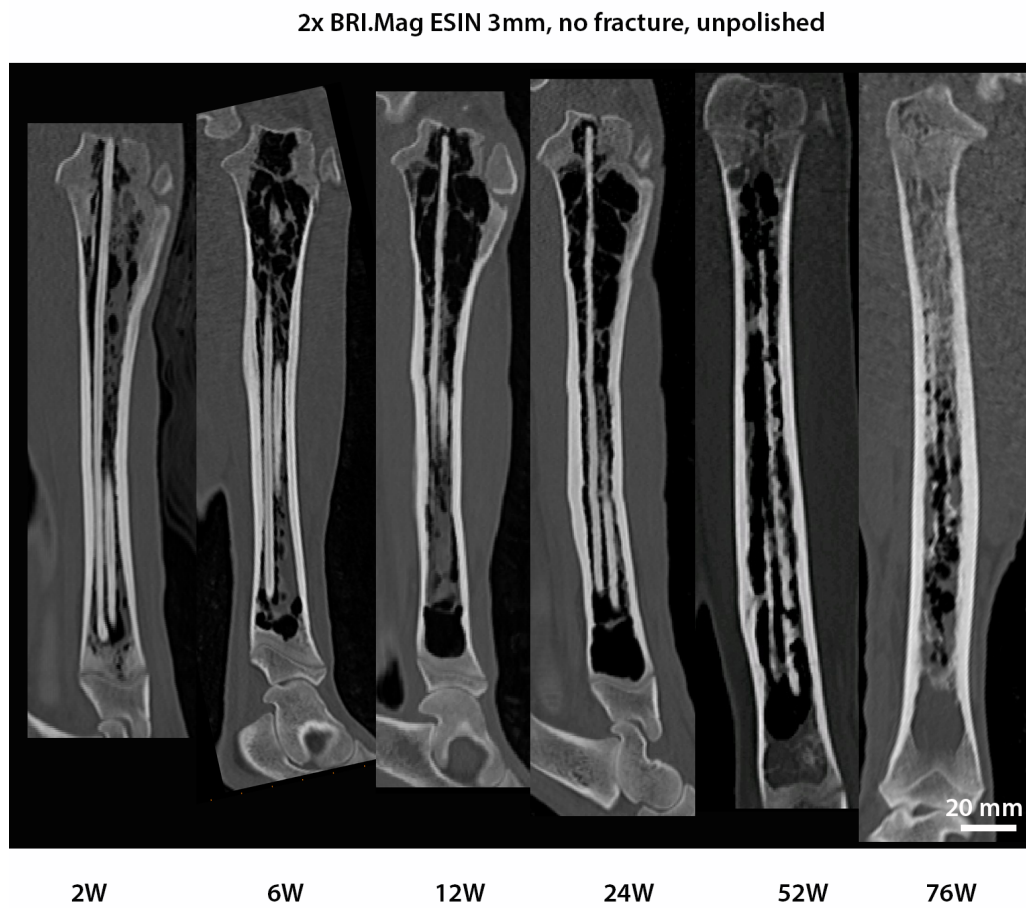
Clinical CT scans were performed after 2W, 6W, 12W, 24W, 52W and 76W in vivo at the Department of Radiology, Medical University of Graz.
